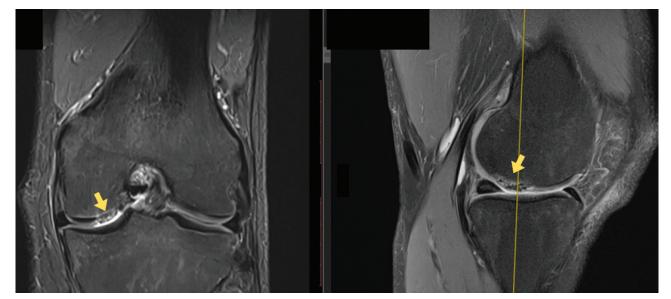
1 year postoperative magnetic resonance imaging showing complete fill of the cartilage defect (arrows) with good integration, no subchondral bone defect and no subchondral oedema
